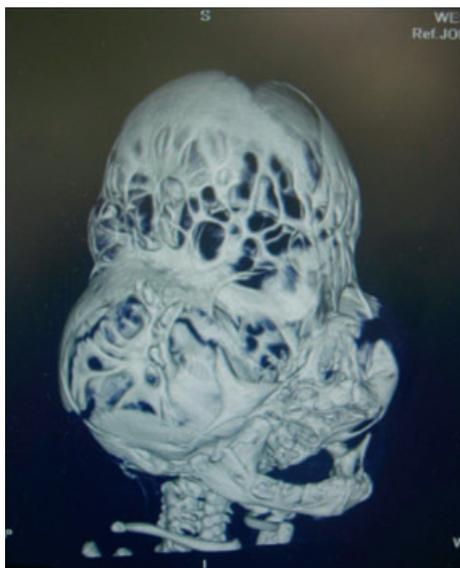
3D CT Scan of neonate with Pfeiffer syndrome demonstrating craniolacunae in a cloverleaf skull.
